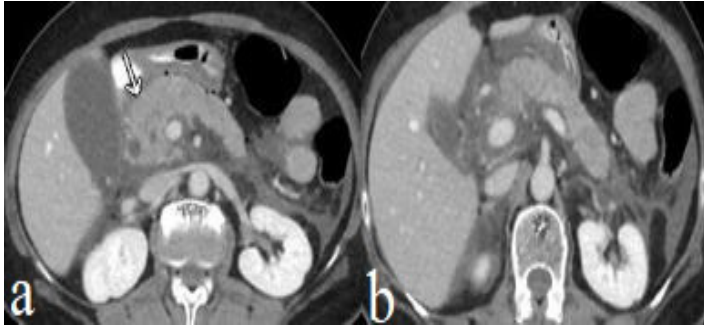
A female patient with acute pancreatitis, 61 years old. Axial CT images reveal pancreatic head enlargement (a) and peripancreatic fluid (b).
